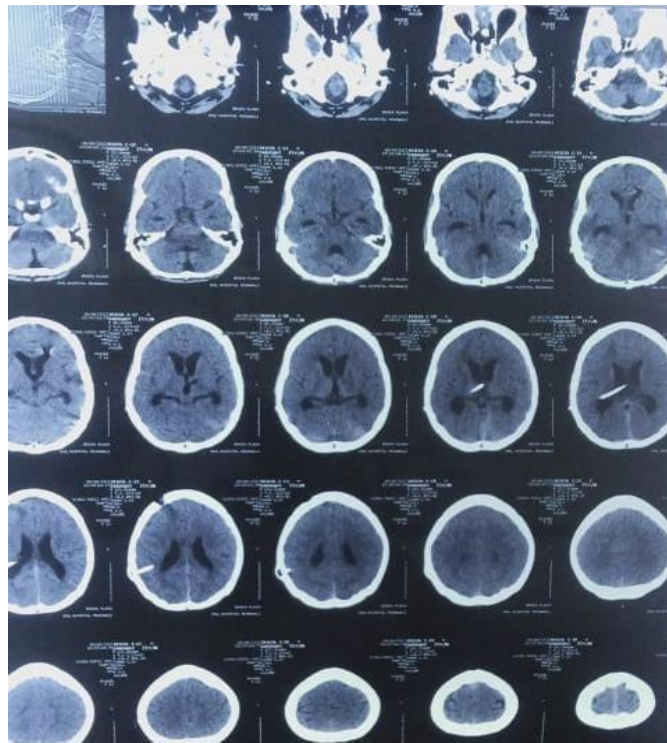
Post op CT scan showing normal size ventricles.
